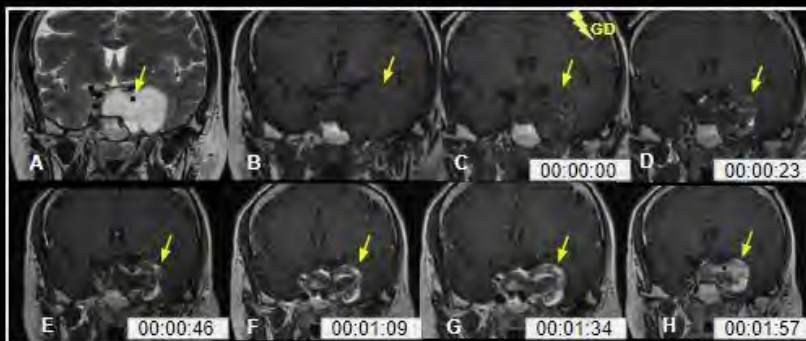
57-year-old female presenting with left hemifacial paresthesia, left-sided ptosis and diplopia. Coronal MR images showed a hyperintense mass on T2WI (A) centered at the left cavernous sinus and the widened sella turcica, involving the left internal carotid artery without its narrowing (arrow in A). DCE sequence (B - H) showing a typical gradual "filling in" pattern of enhancement (arrows in B-H), consistent with hemangioma.
